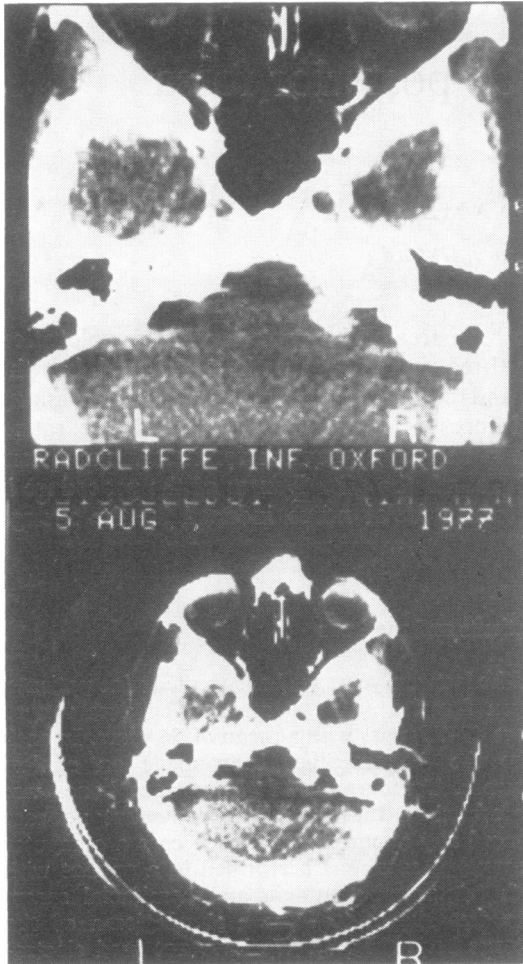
CT scan to show meningioma arising from the right cerebellopontine angle.
